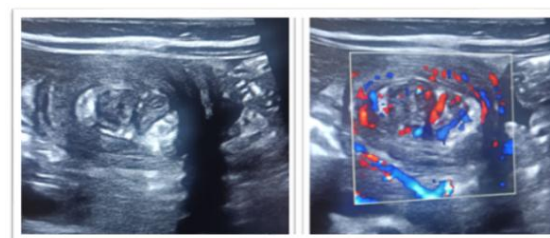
Grayscale ultrasound image on the left shows bowel-within-bowel appearance with characteristic target/doughnut sign in the right upper abdomen. Color Doppler image on the right shows vascularity within the intussuscepted bowel segment, suggestive of ileocolic intussusception.
